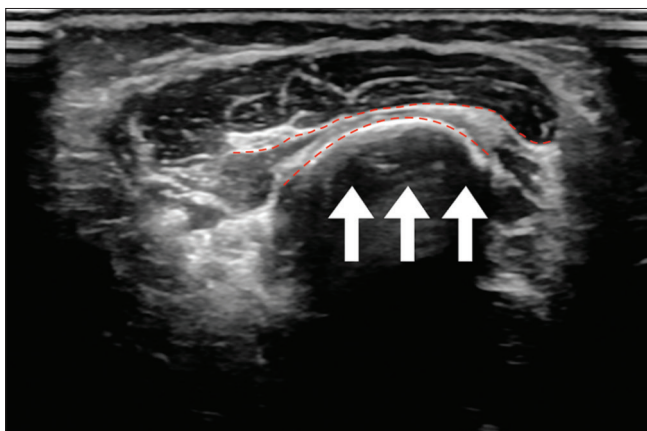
Sagittal high-resonance ultrasound view of the left antecubital fossa showing displacement of the distal humerus (arrows) onto the brachial artery (red) with extensive soft-tissue scarring. The brachial artery deformity measured to be 2.6 cm in craniocaudal length.
